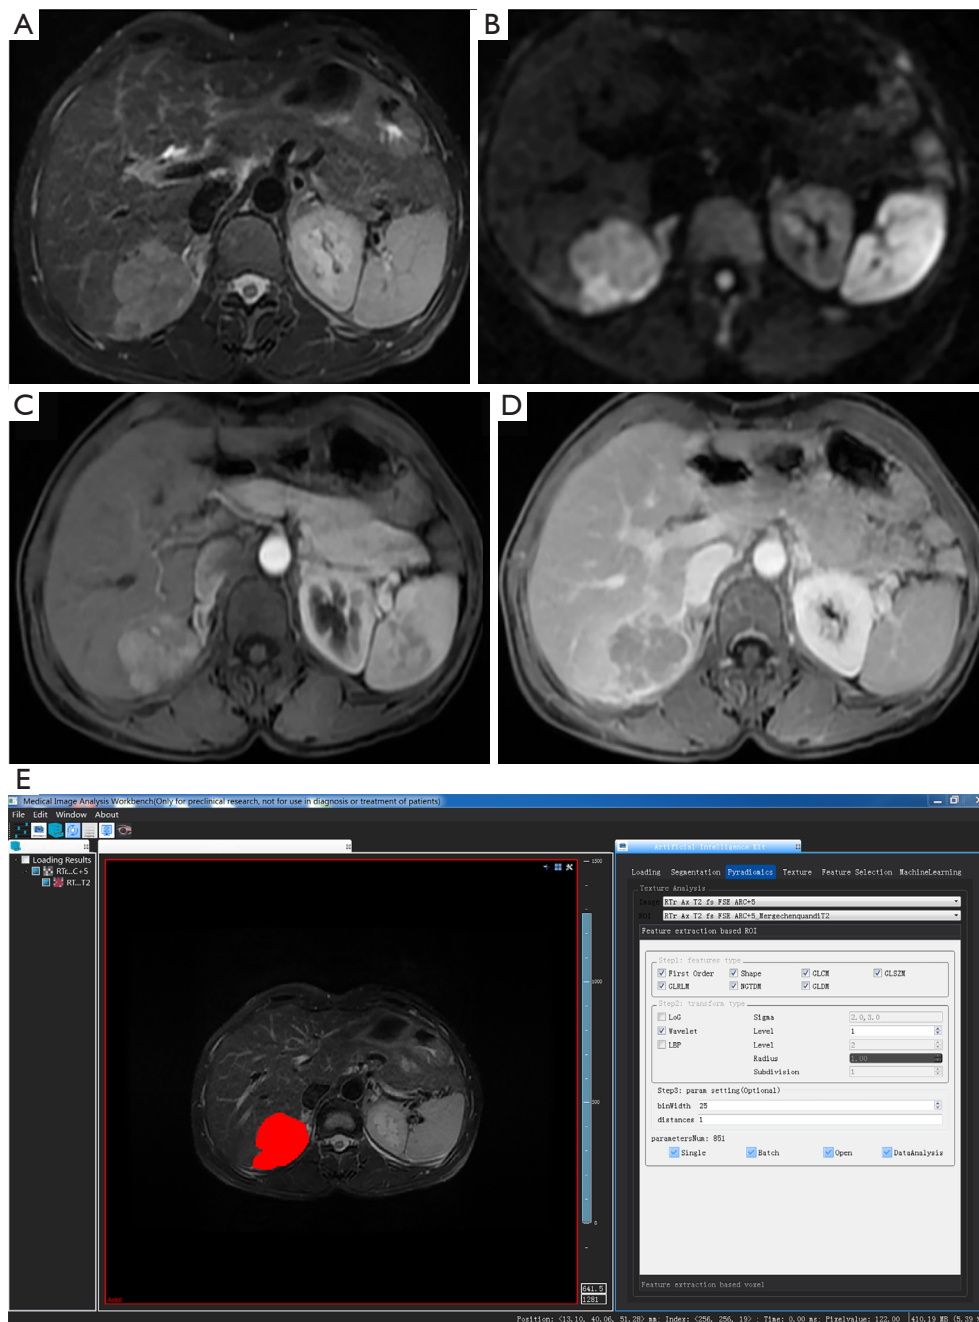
The parameter settings for feature extraction using AK software (Artificial Intelligence Kit Version; V. 3.2.0R, GE Healthcare). A 33-year-old male patient. The physical examination revealed a huge space-occupying mass in the right posterior lobe of the liver. (A) Fat-suppressed-T2WI and (B) DWI showed a high-intensity space-occupying mass in the right posterior lobe of the liver; (C) the arterial phase of DCE-MRI showed obvious and inhomogeneous enhancement; (D) the portal-venous phase of DCE-MRI showed markedly decreased enhancement and pseudo-capsule enhancement using fast wash-in and wash-out; (E) the ROI is outlined in the lesion areas and parameter setting. T2WI, T2-weighted image; DWI, diffusion-weighted image; DCE-MRI, dynamic enhancement magnetic resonance imaging; ROI, region of interest.
